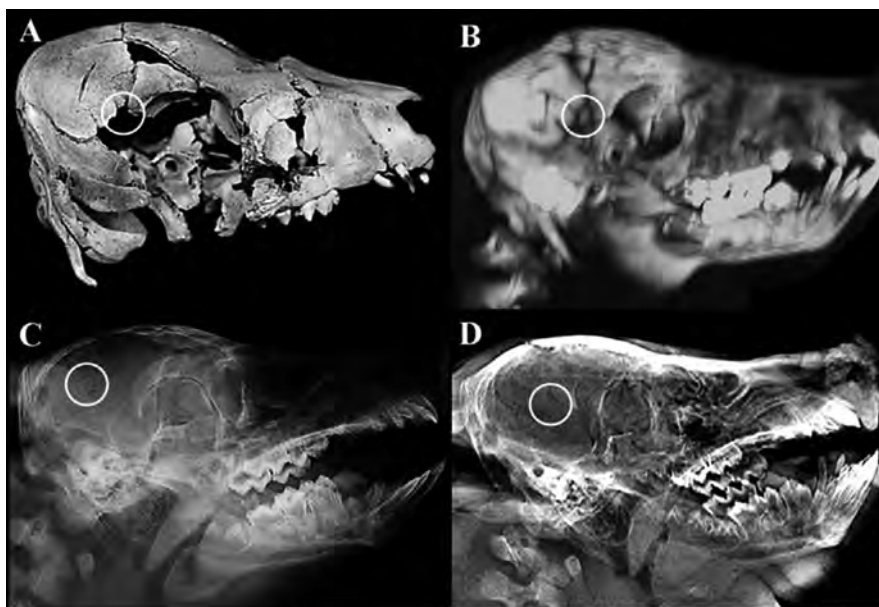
Depressed fracture of the parietal bone as seen on dry bone (A), CT (B), X-ray (C), and Lodox® (D), with central depressed part (white circle), and radiating and concentric fracture lines. Individual radiating and concentric fracture lines were not counted, and this was only scored as one depressed fracture
